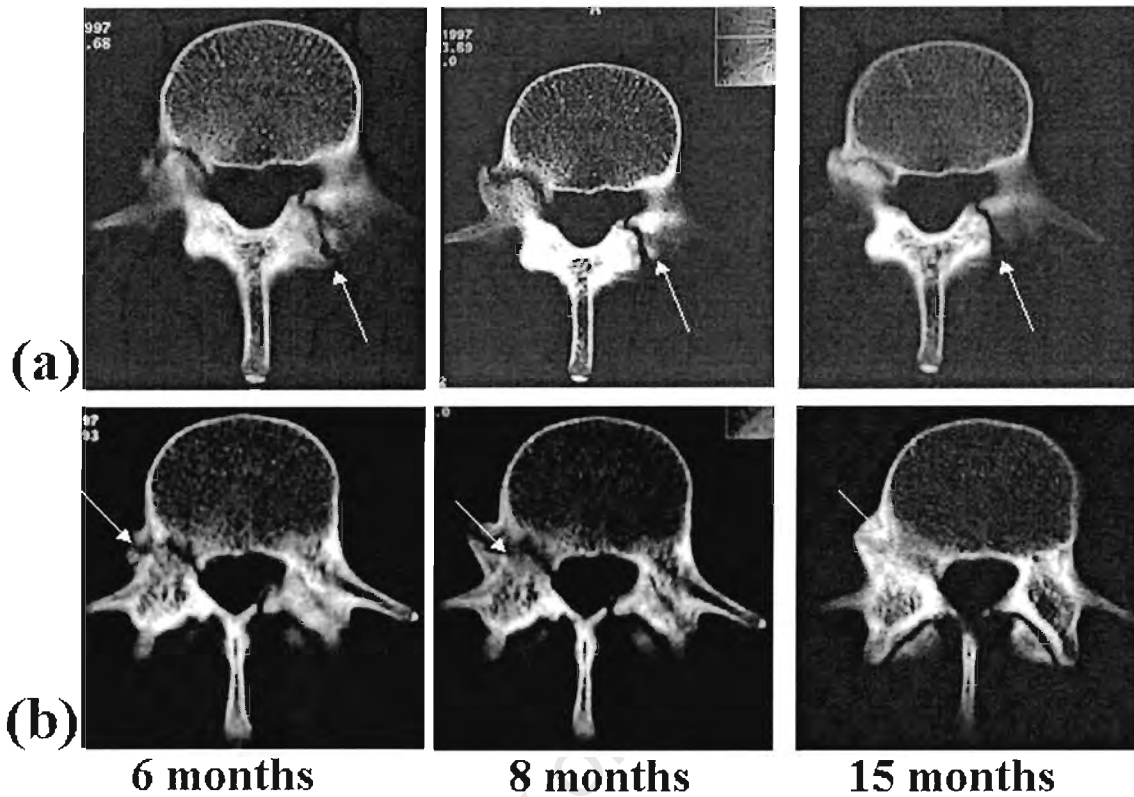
A CT scan in a 17-year-old right arm bowler which shows (a) non bony union of the left pars interarticularis of the 4th lumbar vertebra, 6, 8 and 15 months after the original symptoms, and (b) shows partially united fracture of the right pedicle of the 4th lumbar vertebra after 6, 8 and 15 months.
